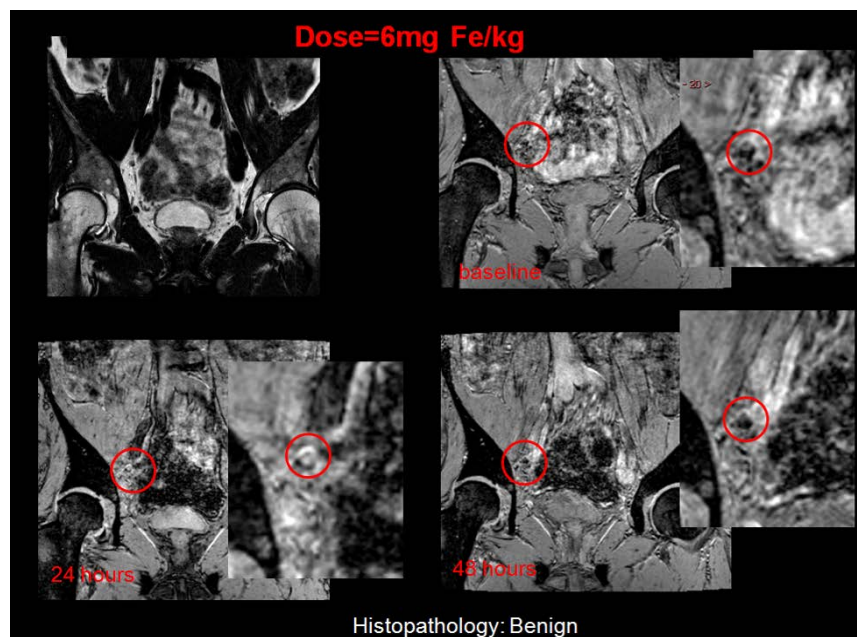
Coronal T2* weighted MRI at the baseline scan demonstrates a right iliac chain lymph node, 24 and 48 hours follow up scans after 6mg Fe/kg Ferumoxytol injection demonstrate a heterogeneous signal drop within the lymph node.
